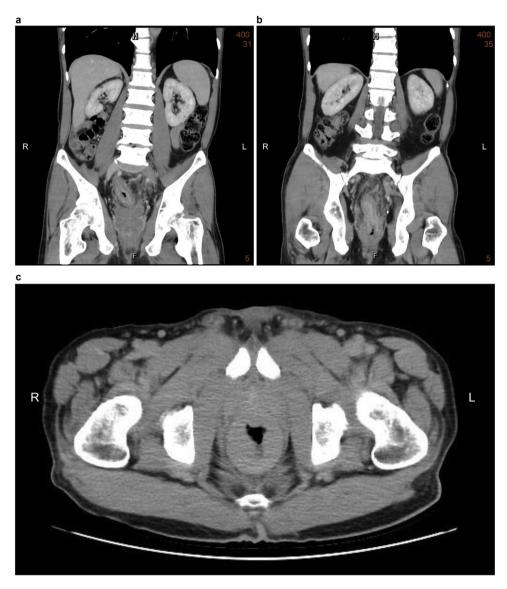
Computed tomographic image showing contiguous symmetrical rectal wall thickening.
